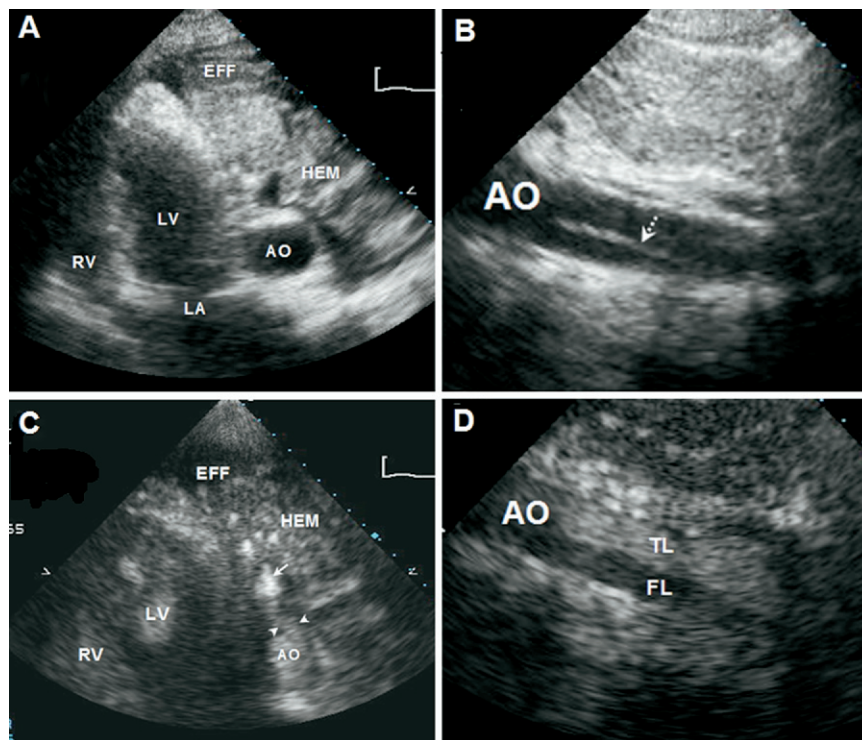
A and C: Apical four chambers without and with contrast, respectively. B and D: Abdominal aorta without and with contrast, respectively. Site of aortic rupture with active extravasations of contrast into left pleural cavity (*arrowheads*). Contrast in left pleural cavity (*solid arrow*). Abdominal aorta intimal flap (*dotted arrow*). *EFF*, Left pleural effusion; *HEM*, hematoma; *AO*, aorta; *LV*, left ventricle; *RV*, right ventricle; *LA*, left atrium; *TL*, true lumen; *FL*, false lumen.
